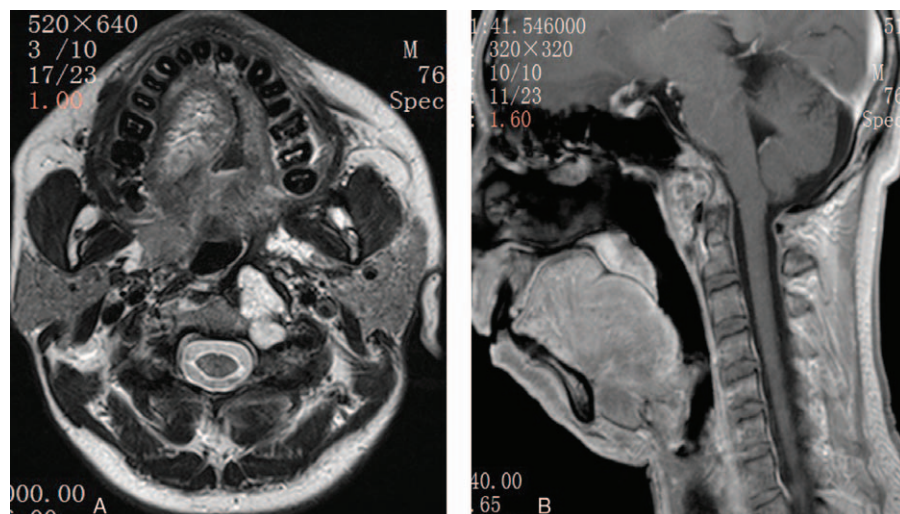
MRI revealed block signal images at the (A) left retropharyngeal space and (B) clivus.
